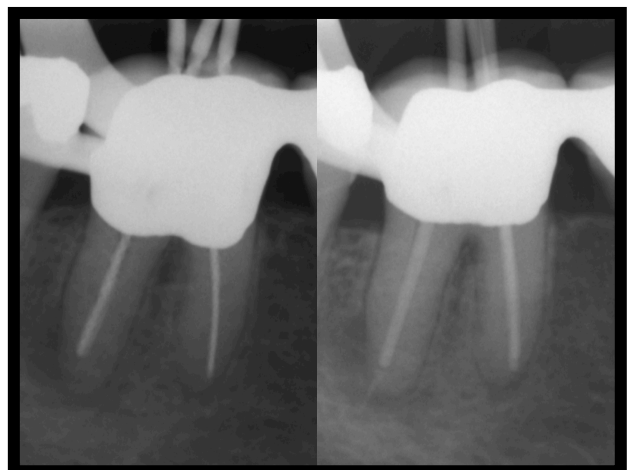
Working length and masterpoint radiographs
